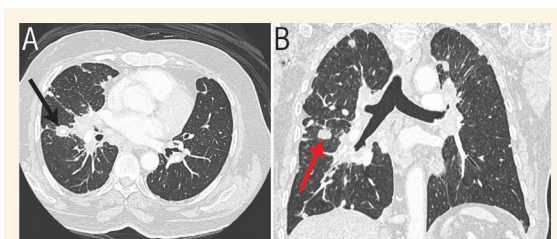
High resolution computed tomography scans of the chest of a 71-year-old male patient (case one) in (A) axial and (B) coronal views showing bilateral pulmonary nodules (black and red arrows) and central calcification in the right upper lobe nodule (red arrow).
